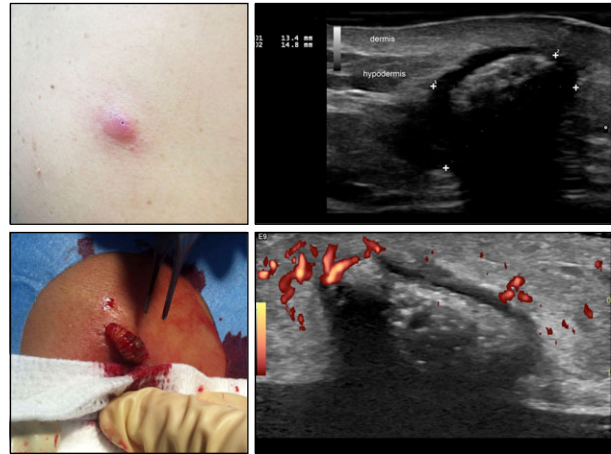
Clinical, ultrasound (grey scale and colour Doppler) and surgical images of the *Dermatobia hominis* larva parasitic infection.
